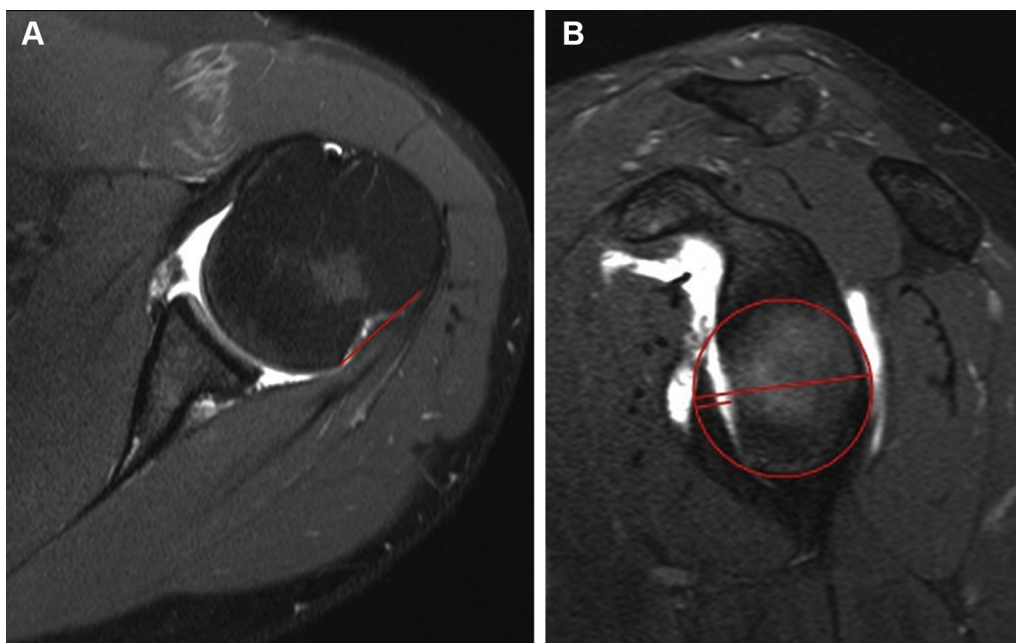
Magnetic resonance images demonstrating the calculation of GT. (A) The Hill-Sachs interval corresponds to the distance between the inner margin of the footprint of the rotator cuff and the medial border of the bone defect. (B) From a virtual circle traced in the lower two-thirds of the glenoid, having as reference its intact edges, we obtained the measure that would be the diameter of the same in the absence of the bone defect and the width of the bone defect. The GT corresponds to 83% of the glenoid diameter minus the value of the bone defect. *GT*, glenoid track.
